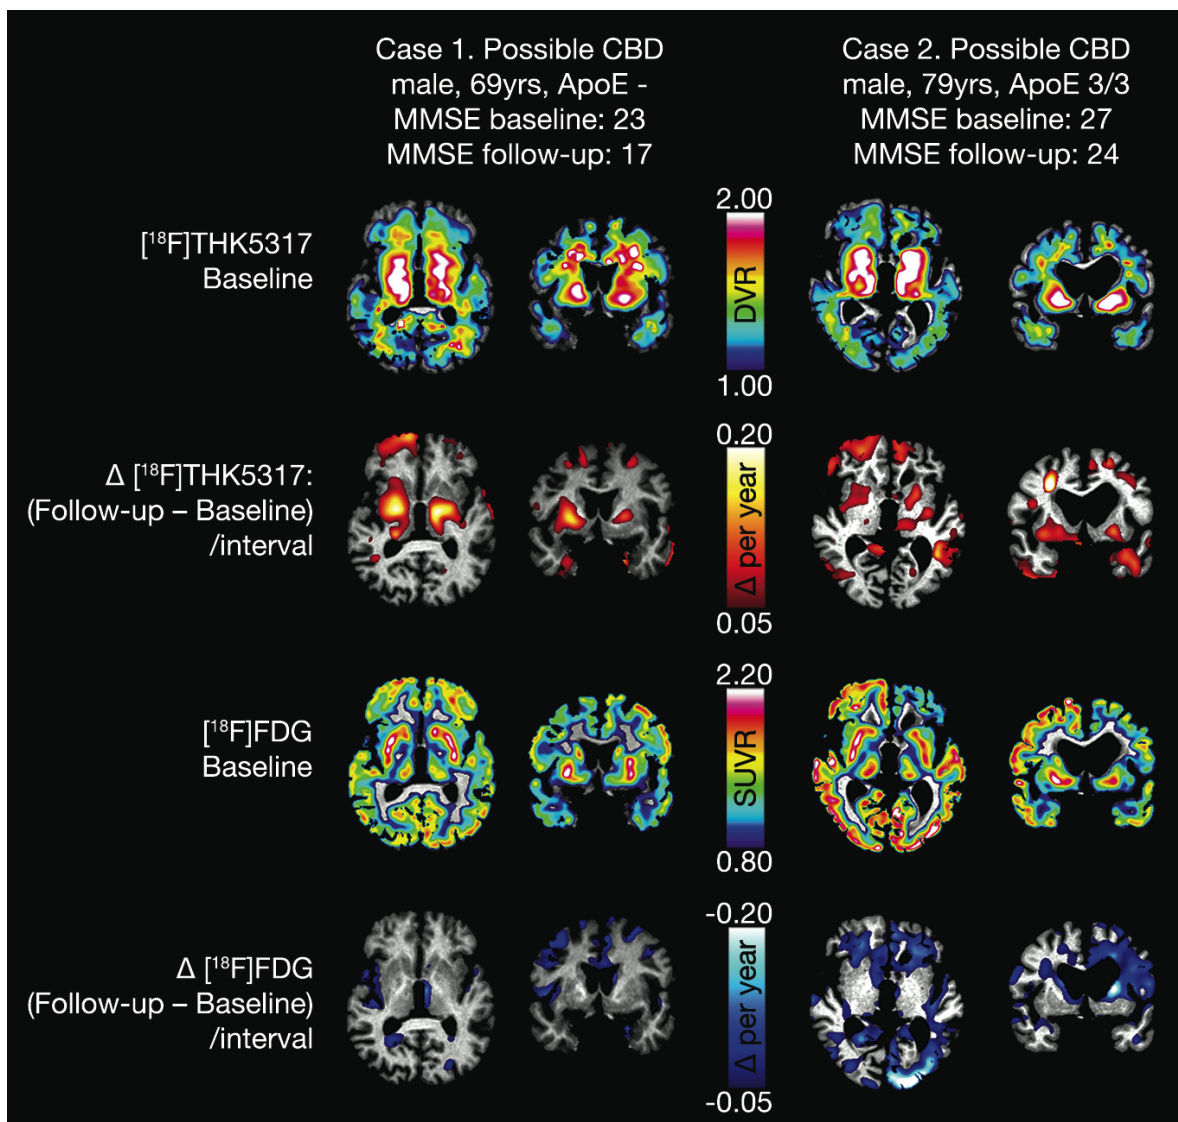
[^{18}F]THK5317 DVR and [^{18}F]FDG SUVR baseline images as well as annual rate of change maps (Δ DVR/SUVR per year) for the binding/uptake of the two tracers in the two patients with clinical diagnosis of possible CBD. The figure is adapted from Chiotis, K. *et al.* Longitudinal changes of tau PET imaging in relation to hypometabolism in prodromal and Alzheimer's disease dementia. *Molecular psychiatry*, (2017).
